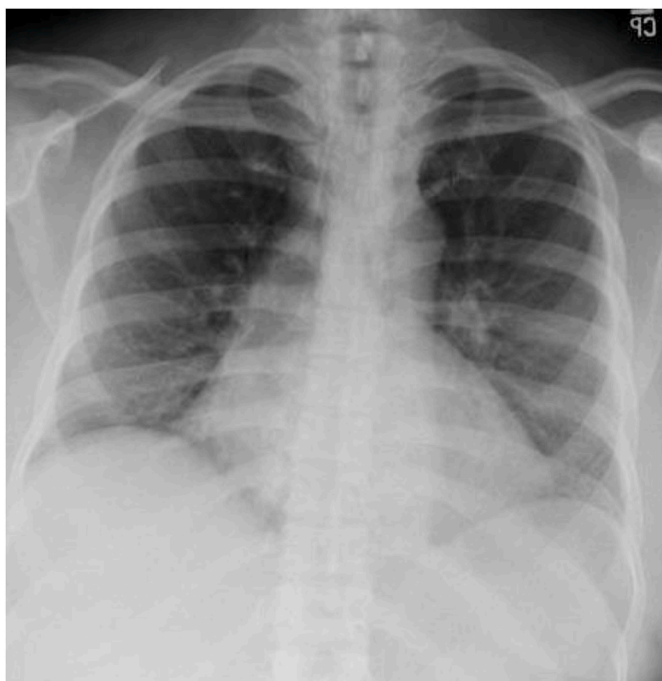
Chest X-Ray two months after initiation of treatment with steroids. Chest x-ray 2 months after treatment with corticosteroids. Bilateral lower zone infiltrates have nearly completely resolved.
